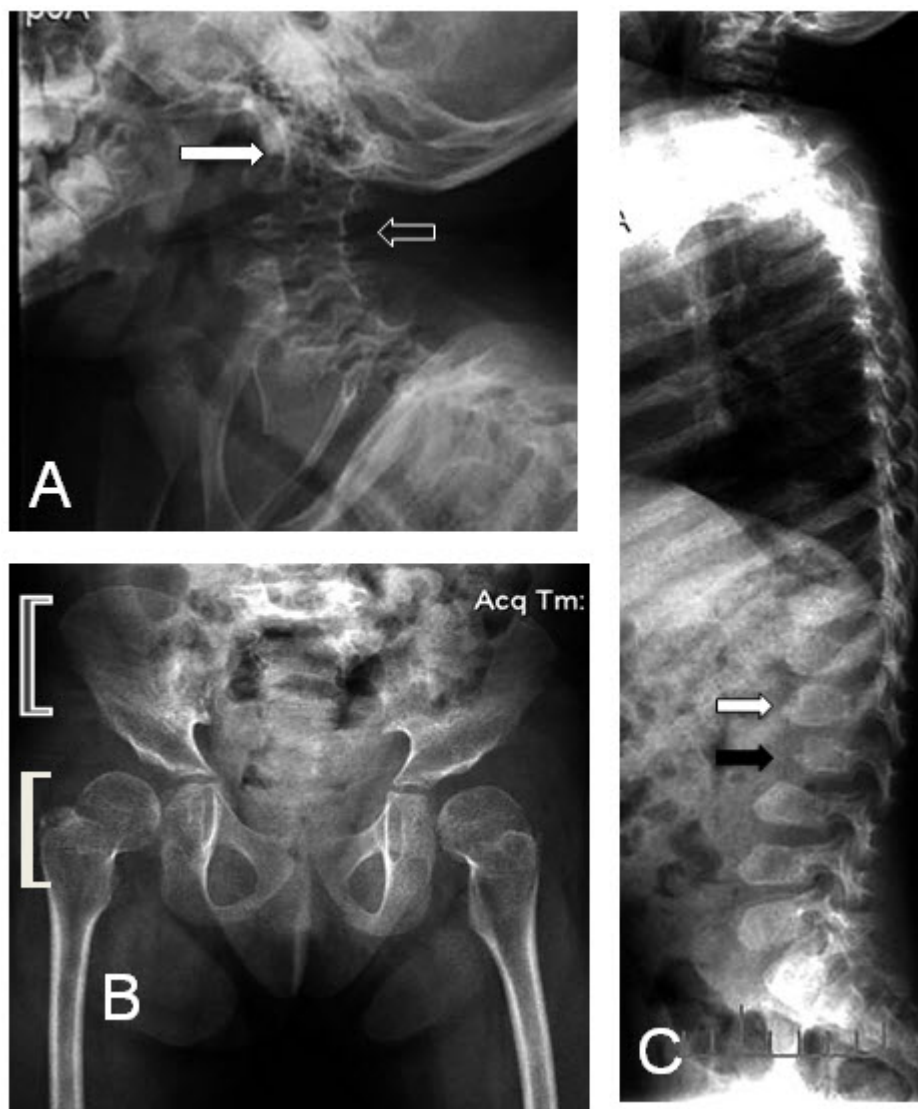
Radiographs of the late-infantile form of GM1 gangliosidosis
